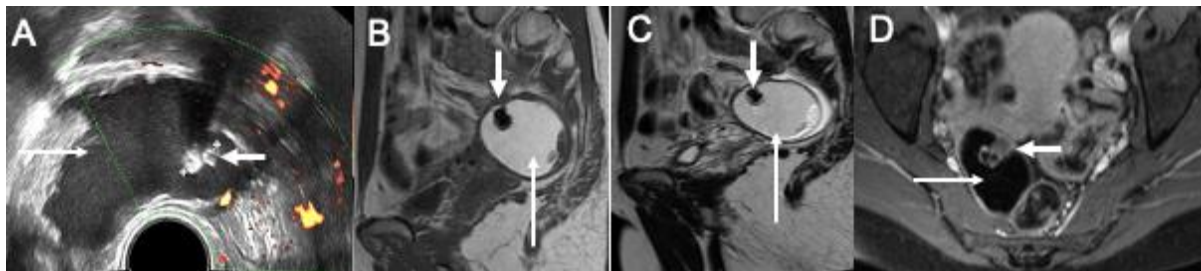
US and MRI of MCT to show a Rokitansky nodule. (short arrows). US (A) shows a unilocular cystic lesion with an echogenic nodule without flow in the Doppler exam. On MR, it is hypointense on T1-weighted (B) and T2-weighted (C), and subtle enhancement contrast (D). The fat tissue component (long arrows) is slightly echogenic on US (A), high signal on T1-weighted (B) and T2-weighted (C), and loss of signal on fat-suppression images (D).
